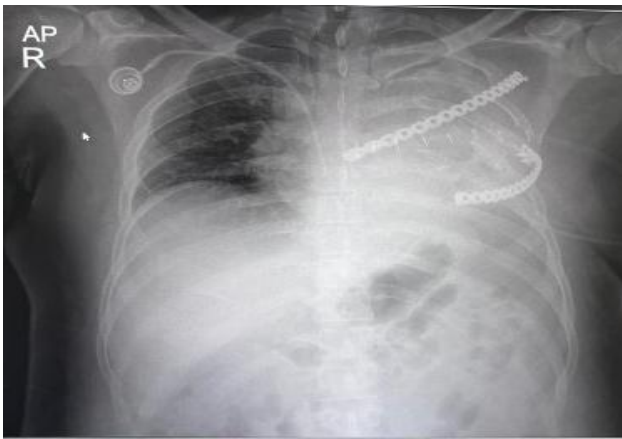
Post pneumonectomy status X-ray.
